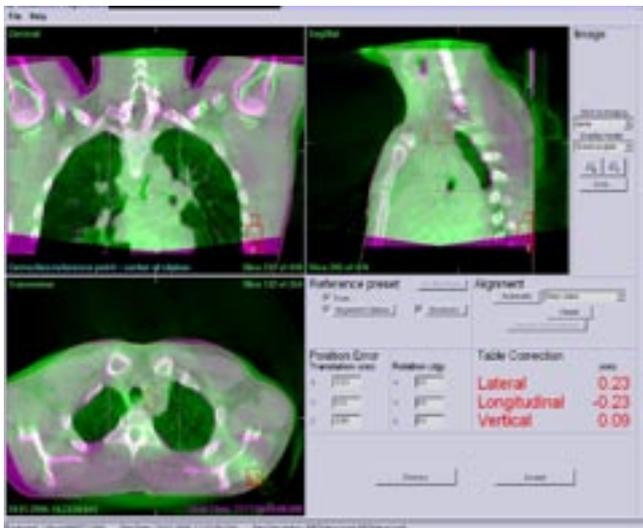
VolumeView™ registration of the target. While the VolumeView™ (in green) shows the patient's arm position in treatment is slightly different from the reference CT (in purple), it does not affect the dose coverage of the PTV.
